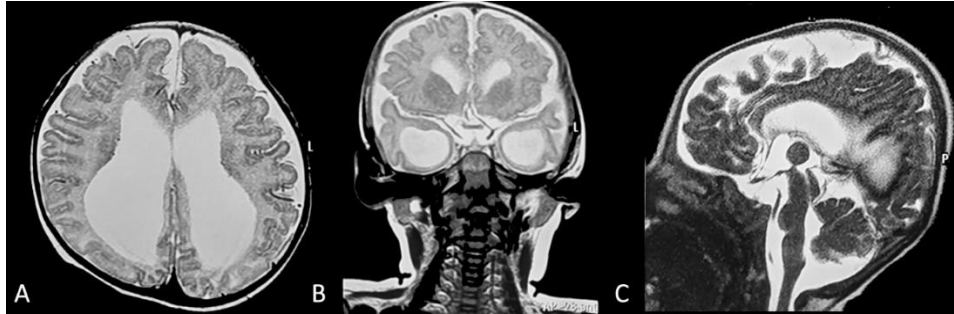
MRI showed craniostenosis on axial (A), coronal (B) and sagittal view (C) with ventriculomegaly suggesting hydrocephalus.
